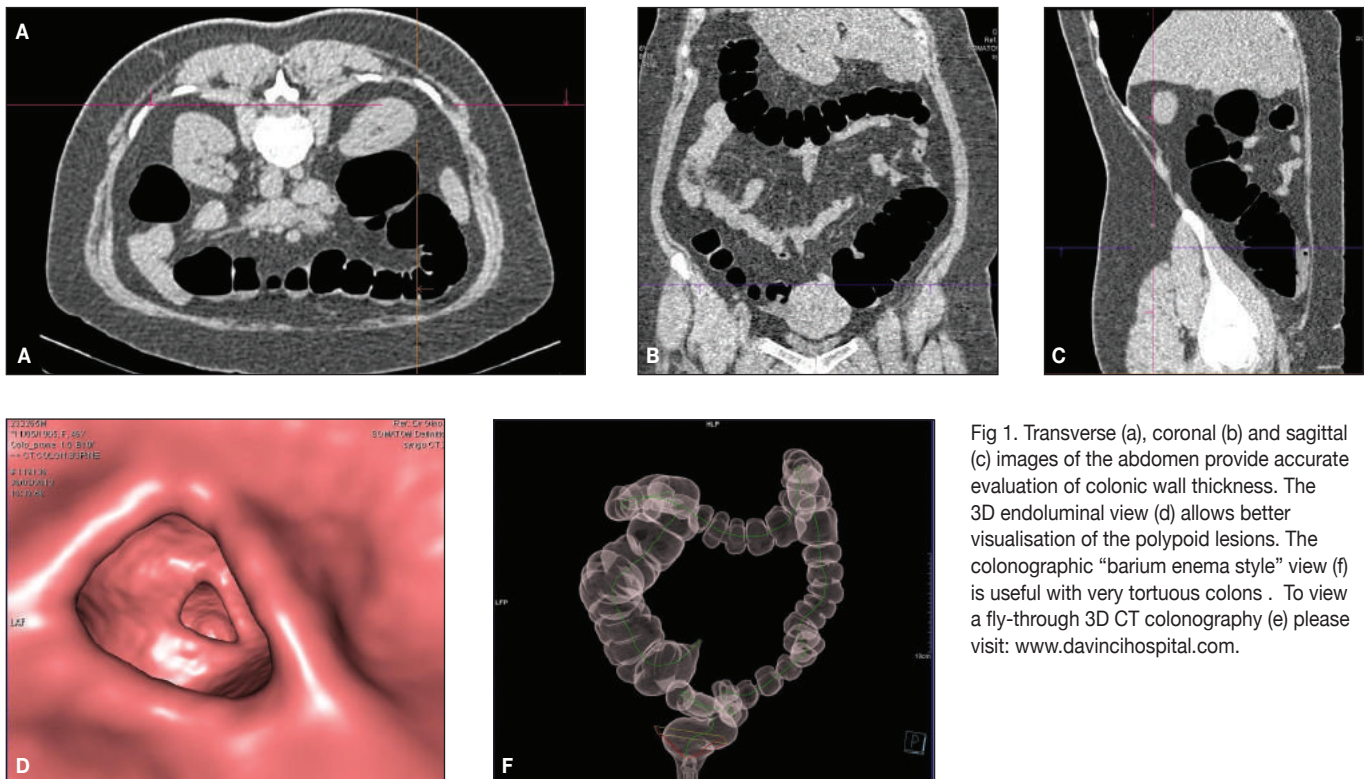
Transverse (a), coronal (b) and sagittal (c) images of the abdomen provide accurate evaluation of colonic wall thickness. The 3D endoluminal view (d) allows better visualisation of the polypoid lesions. The colonographic “barium enema style” view (f) is useful with very tortuous colons. To view a fly-through 3D CT colonography (e) please visit: www.davincihospital.com.
